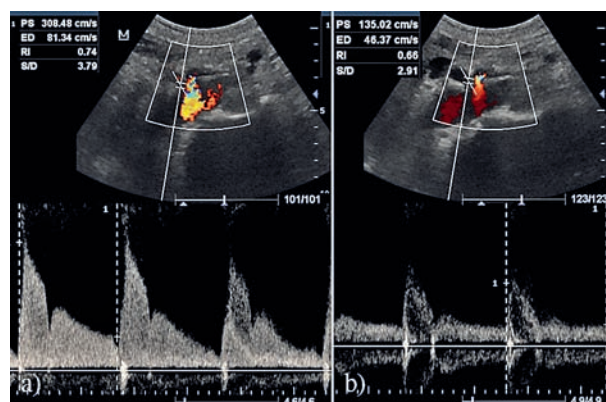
Doppler spectral images of the proximal celiac trunk a) during expiration- peak systolic and end diastolic velocities are elevated (308/81 cm/s); b) inspiration peak systolic and end diastolic velocities decrease to normal values (135/46 cm/s).
